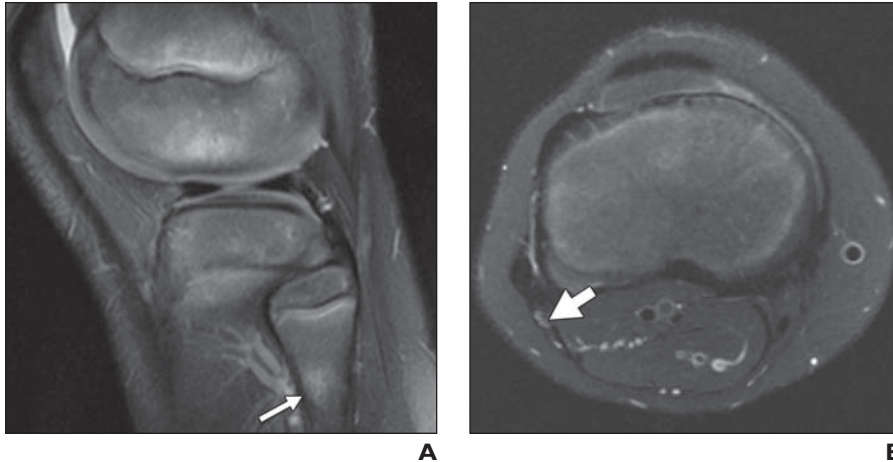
8-year-old girl with persistent left leg pain after buckle fracture of proximal fibula. A, Sagittal fat-suppressed T2-weighted image shows bone marrow edema (arrow) and cortical buckling at fracture site. B, Coronal fat-suppressed T2-weighted image shows mild abnormal T2 hyperintensity of common peroneal nerve (arrow) without fascicular enlargement in case of neurapraxia (mild nerve injury).
